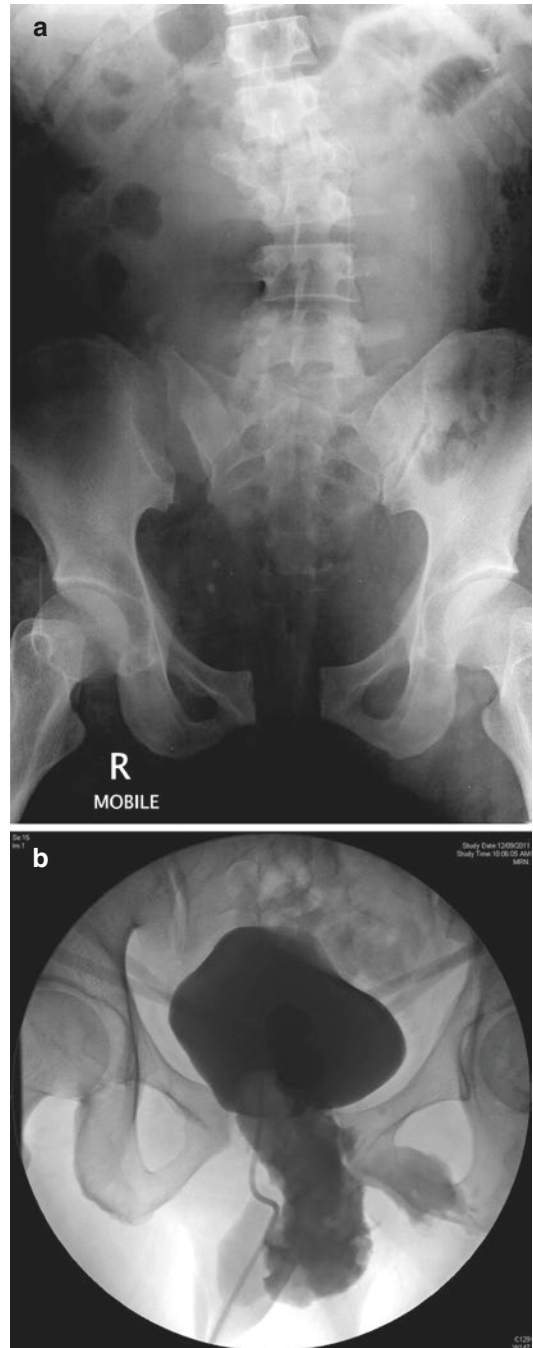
(a) X-ray showing disruption of R hemipelvis at symphysis and R SI joint. (b) Cystogram showing extravasation of dye through tear in the urethra
